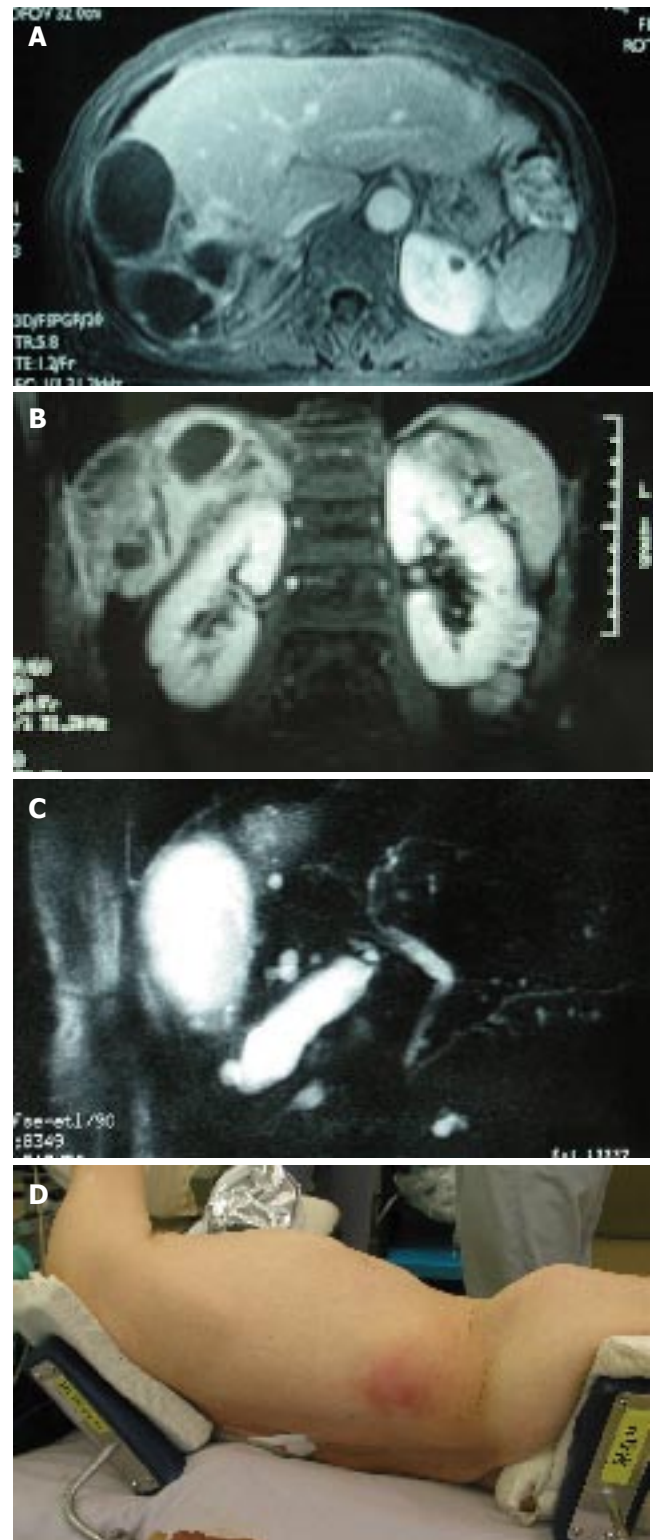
An axial (A) and coronal (B) view of magnetic resonance imaging (MRI) showed a multilocular cyst with a thick wall with a solid component extending into the subcutaneous tissue. MR cholangio-pancreatography showed no dilatation in the biliary system, and most likely no communication with the liver cyst (C). The skin showed red swelling by the subcutaneous extension of the hepatic cyst (D).
